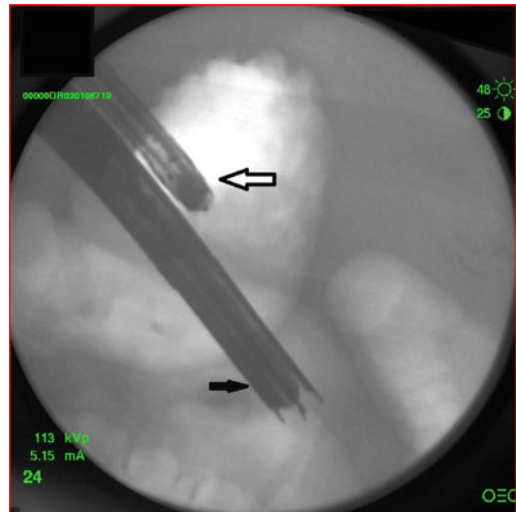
Radiograph of the stapler (black arrow) and endoscope (white arrow), side-by-side, with the stapler cartridge in the pseudocyst
